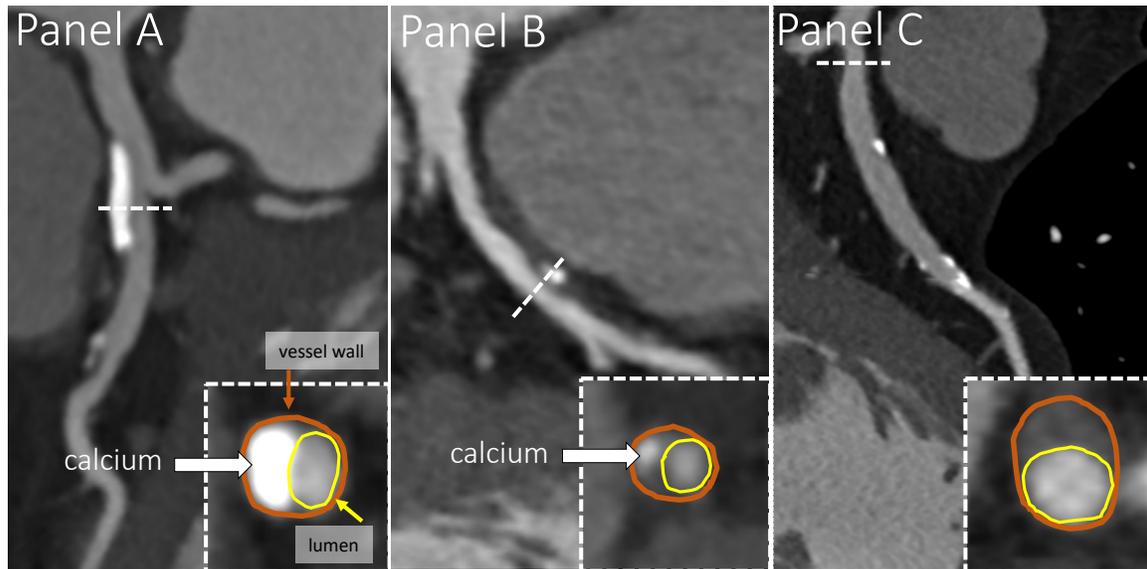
Coronary CTA images showing curved multiplanar views of coronary arteries. Panel A demonstrates a calcified plaque. Panel B shows a partially calcified plaque, and Panel C shows a non-calcified coronary plaque. Orange contours follow the vessel wall and yellow contours show the vessel lumen contour. (Own figure)
